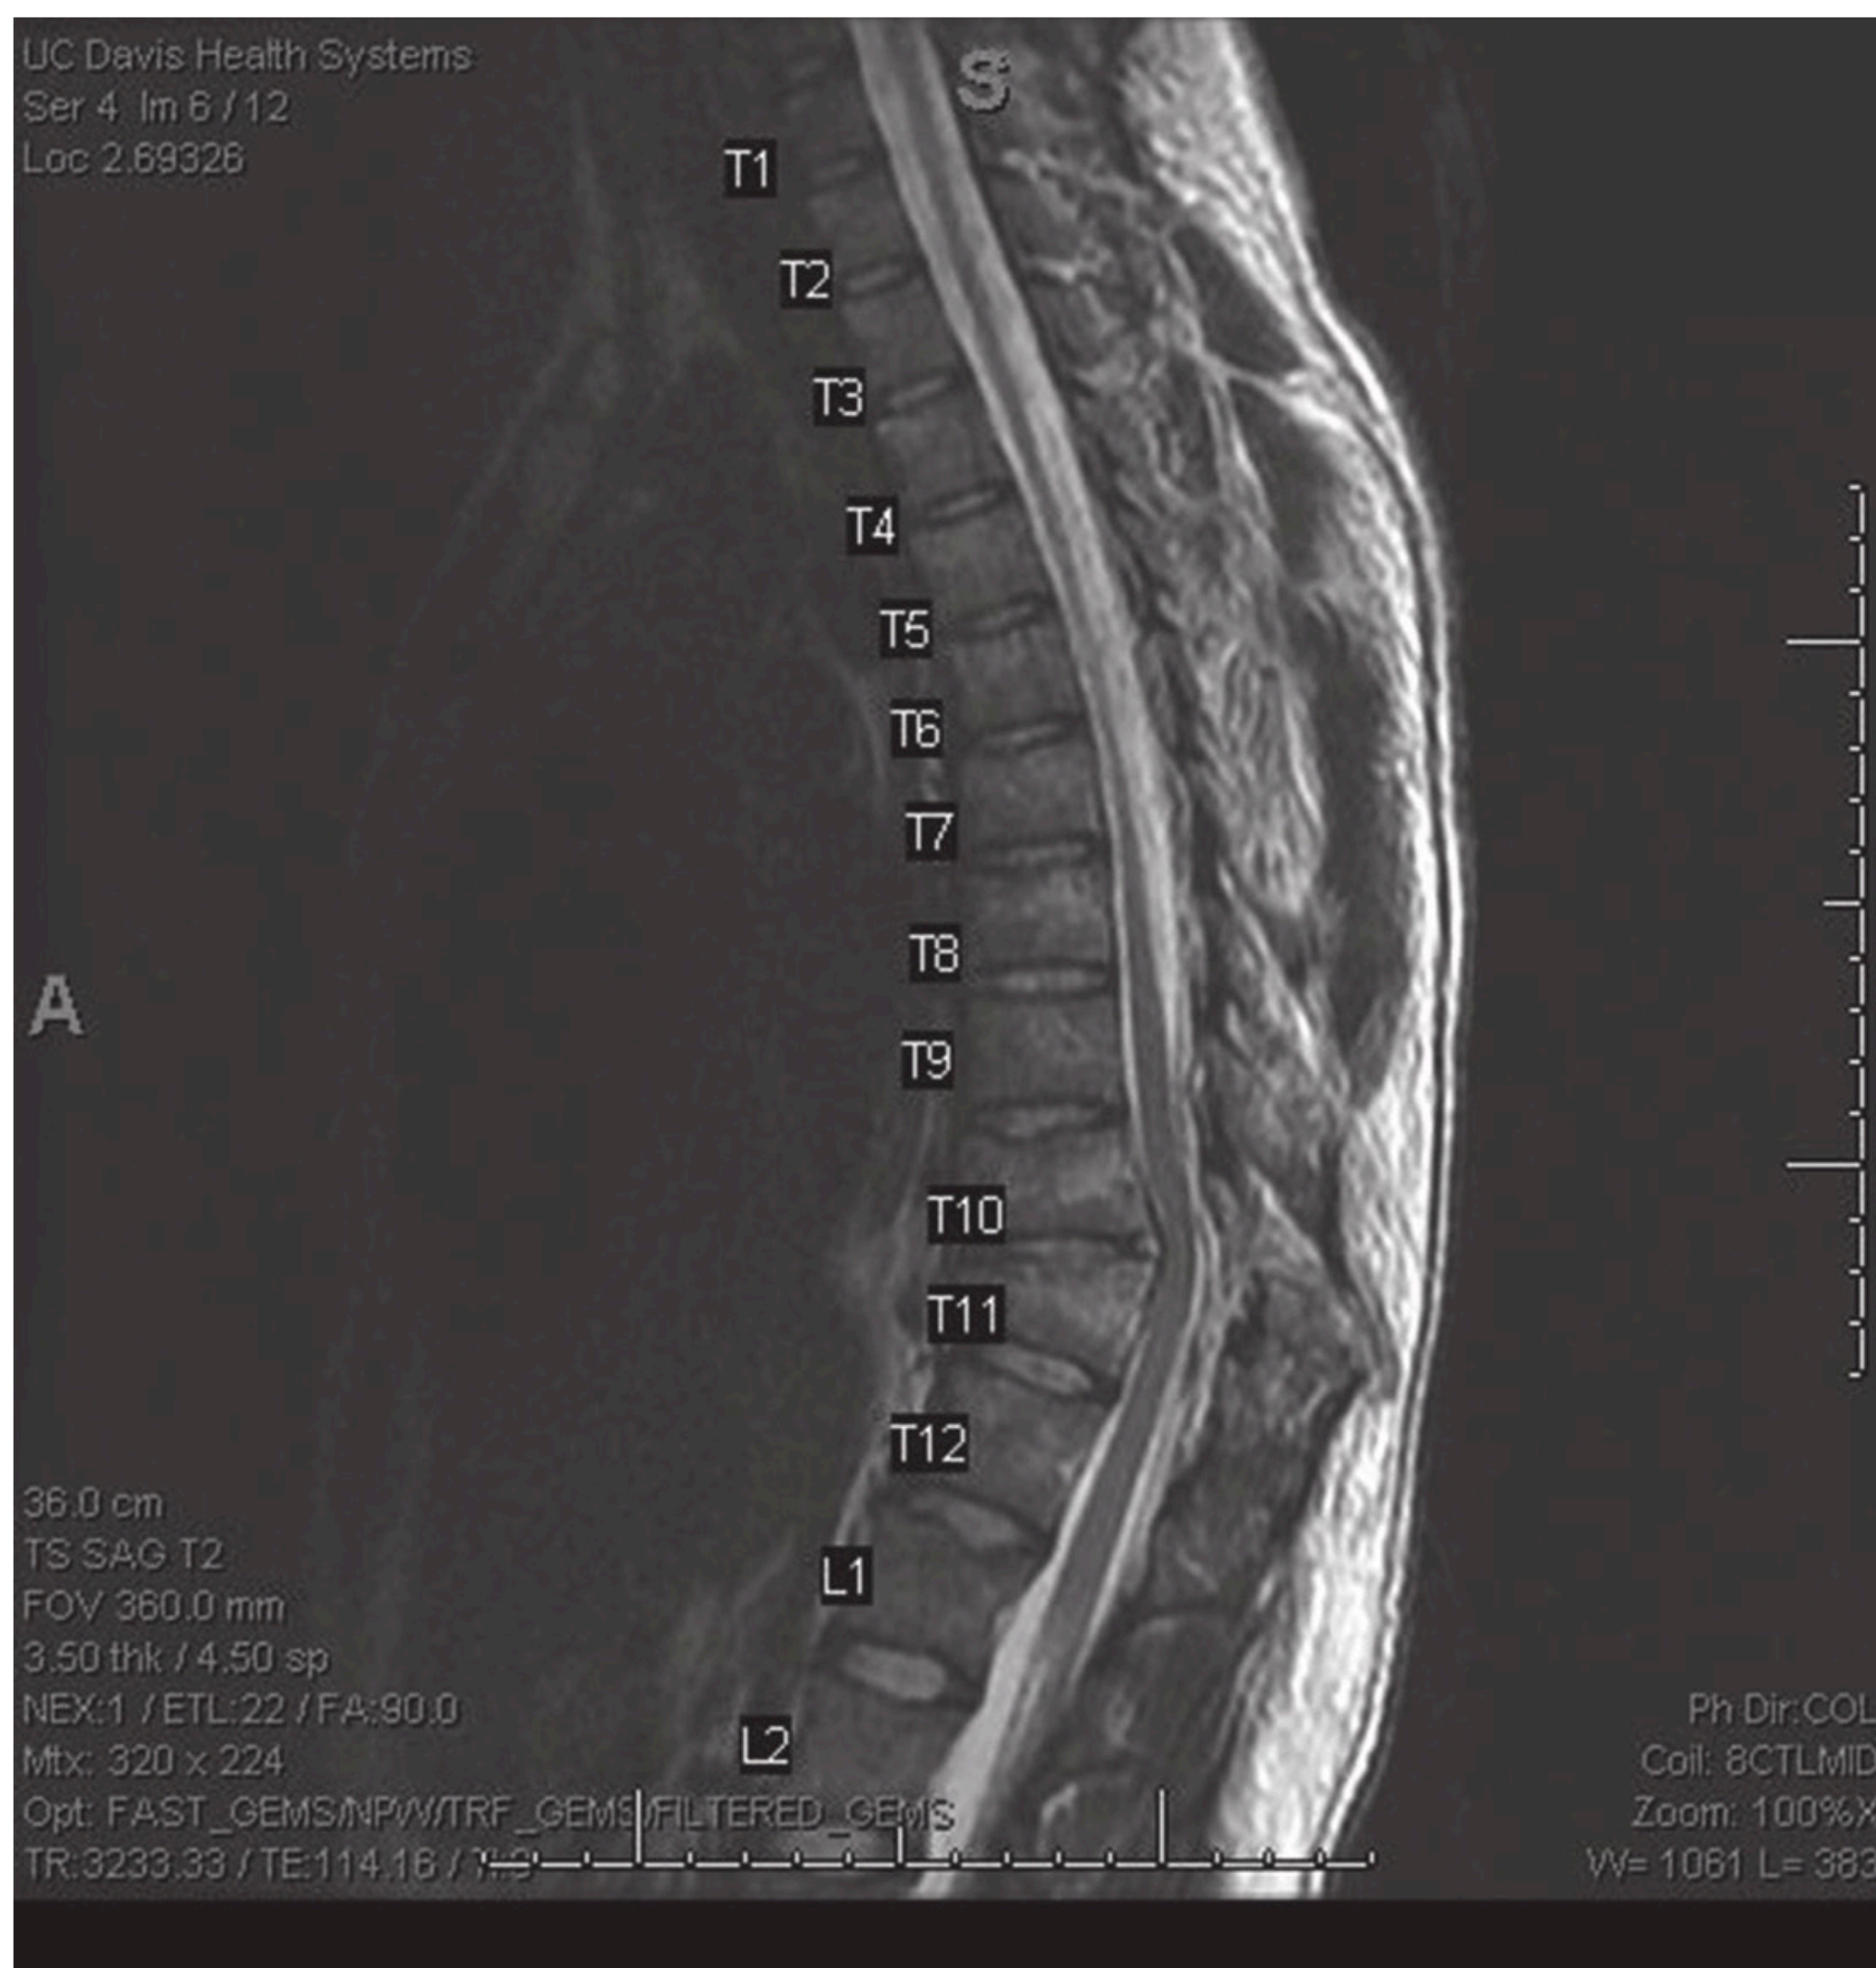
MRI in same patient showed narrowing of the spinal canal with cord compression at that level. Fortunately, the patient was moving his lower extremities.
